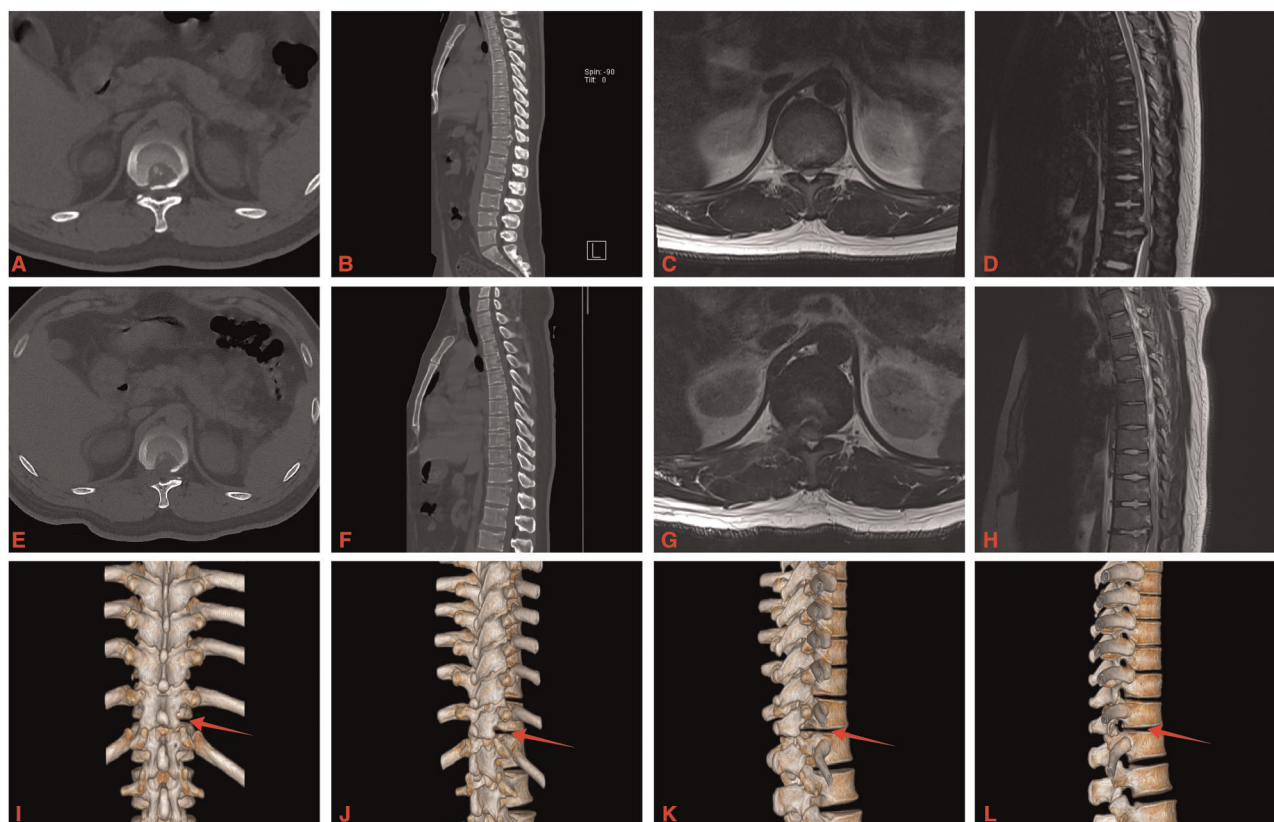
A 46-year-old male with OPLL at T11-12. (A–D) Preoperative CT and MRI showed T11-12 posterior longitudinal ligament ossification and spinal cord was compressed. (E–H) Postoperative CT and MRI showed that the ossified posterior longitudinal ligament was removed and the ventral side of the spinal cord was completely decompressed. (I–L) The three-dimensional reconstruction of the CT images showed right side facet joint of T11-12 was resected (red arrow).
